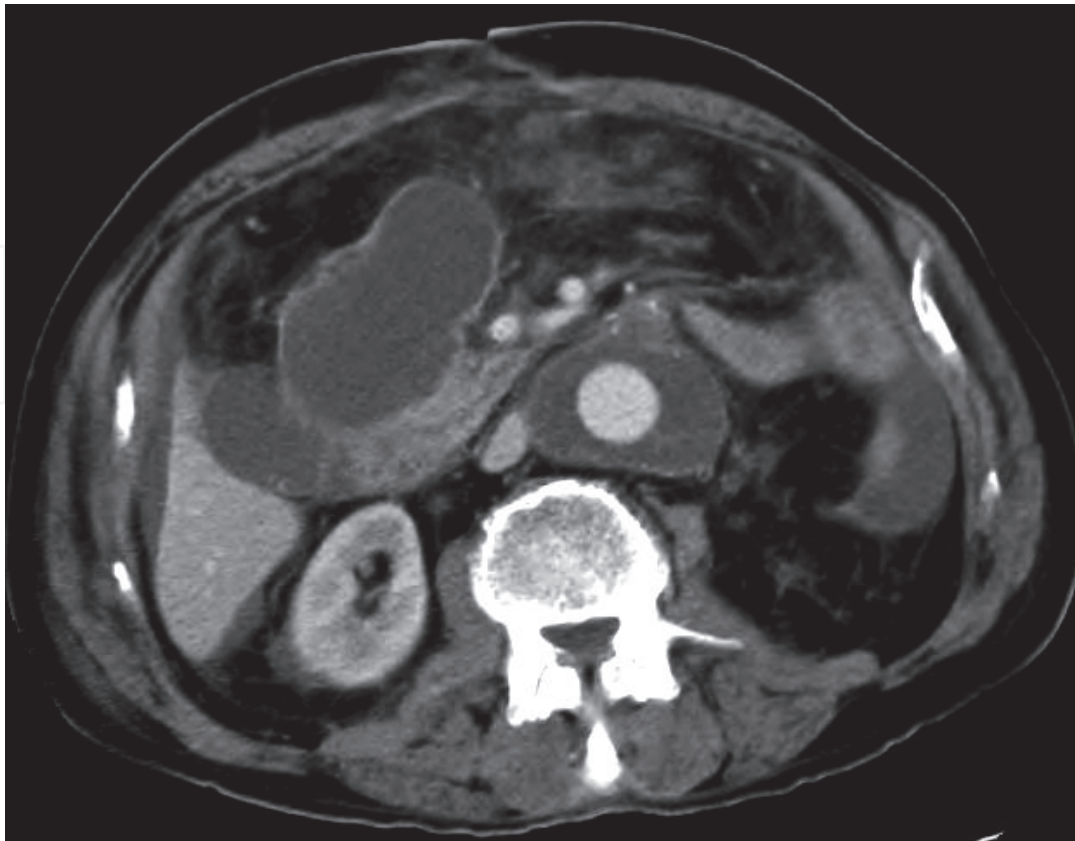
Abdominal CT angiography shown an abscess and perigraft fluid.
